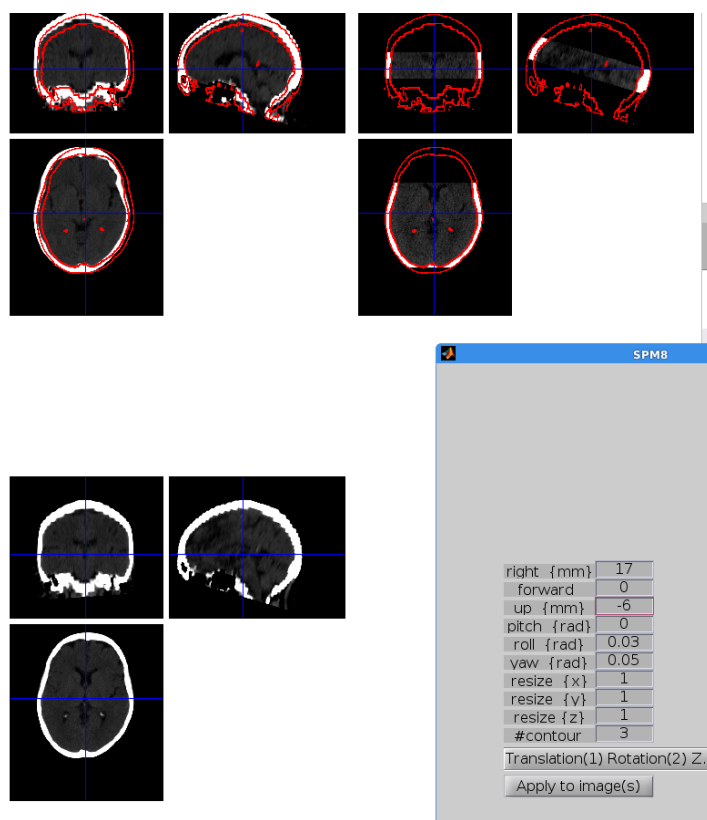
Coregistration of Follow up CT and acute CTP
